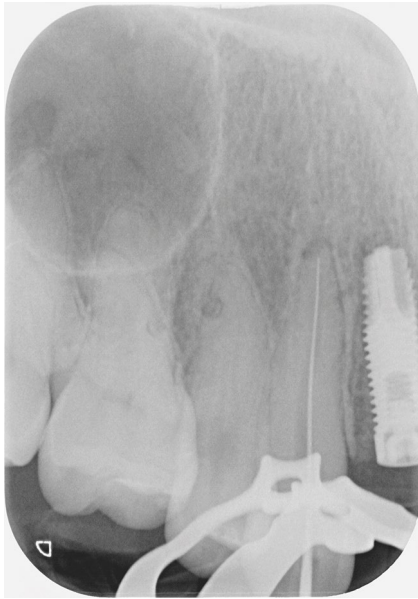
Working length radiograph of the 13 that revealed itself to be non-vital two years post-trauma and soon after implant provision. Note the healed fixation screw defect on the distal portion of the 14 root
